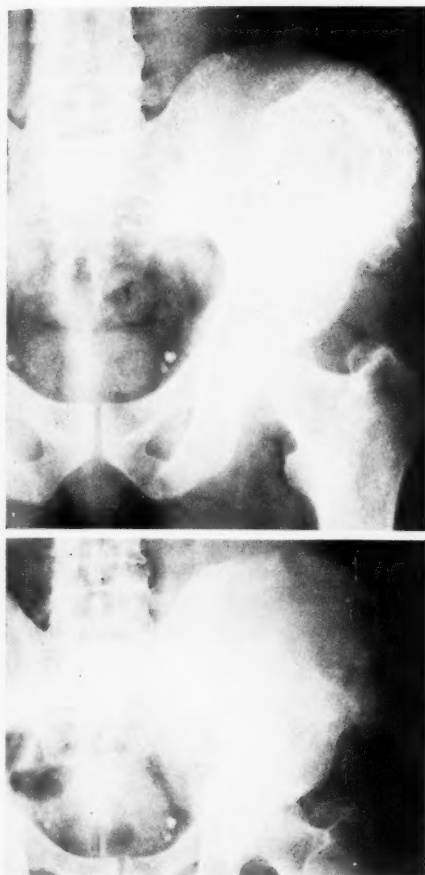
Case 6: Osteochondrosarcoma. The upper roentgenogram (1934) was misinterpreted as a benign osteochondroma. The lower picture (1936) shows extension into the soft tissues with pathologic fracture of iliac crest; diagnosis, osteochondrosarcoma.
